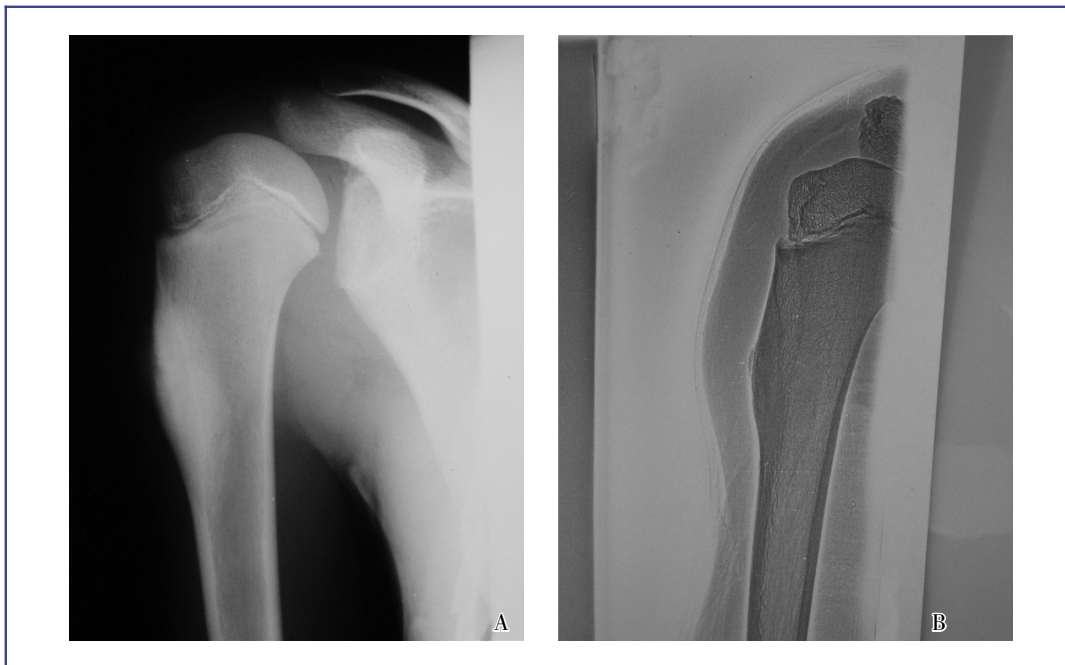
X-ray image and xerograph image of the right shoulder of the 11-year-old patient in November 1982. A, a vague calcified density is shown in the right proximal humerus, seeming to extend down with superficial location and bony attachment. B, xerograph image shows a mass located in the right proximal humerus.
